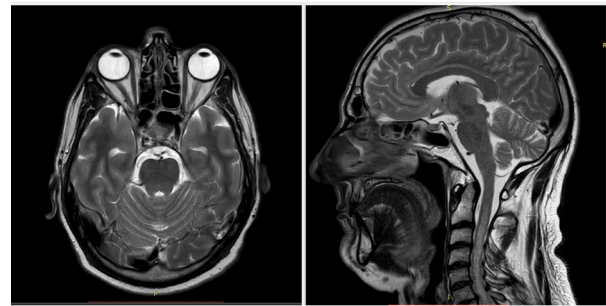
Axial (A) and sagittal (B) T2-weighted images of the brain did not show brain abnormalities, but reveal an extensive cervical spinal cord lesion.
